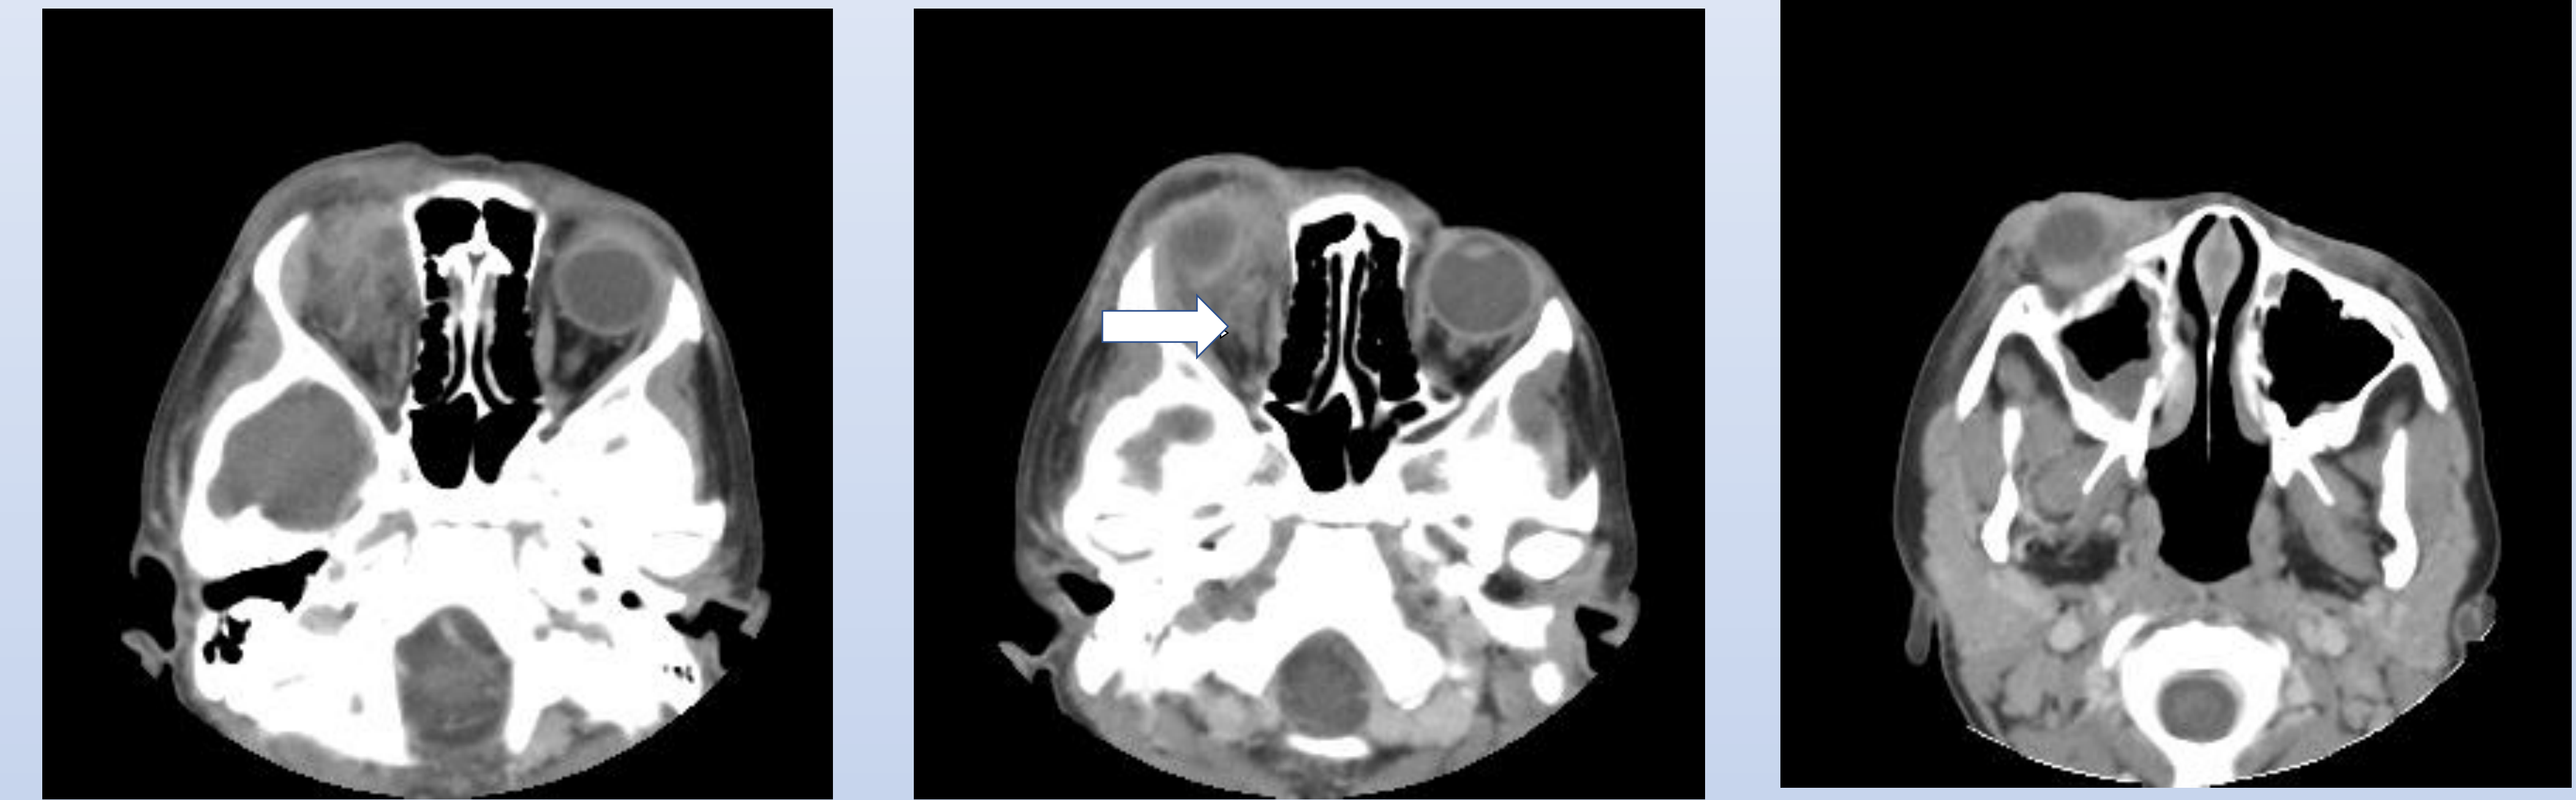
Repeat CT scan revealing a worsening of the right superior ophthalmic vein distension (arrow) and inflammatory changes surrounding the vein. The cavernous sinus was felt to be normal and the maxillary sinus disease had improved
